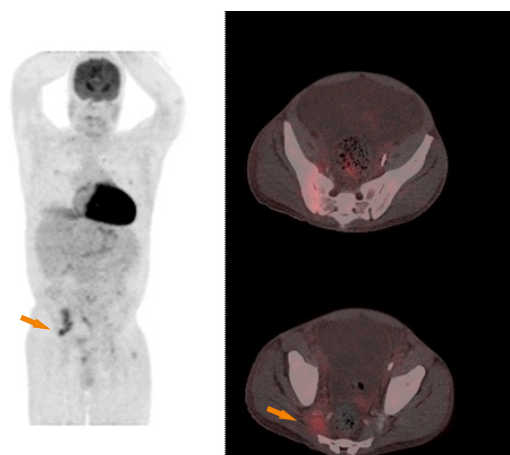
A 25 years old male on hemodialysis for ESRD. Fluorine-18-FDG-PET/CT showed tracer accumulation in the right sacroiliac joint which was later confirmed to be due to Staphylococcus aureus-causing sacroiliitis and a right peri-anal abscess. (arrows)
